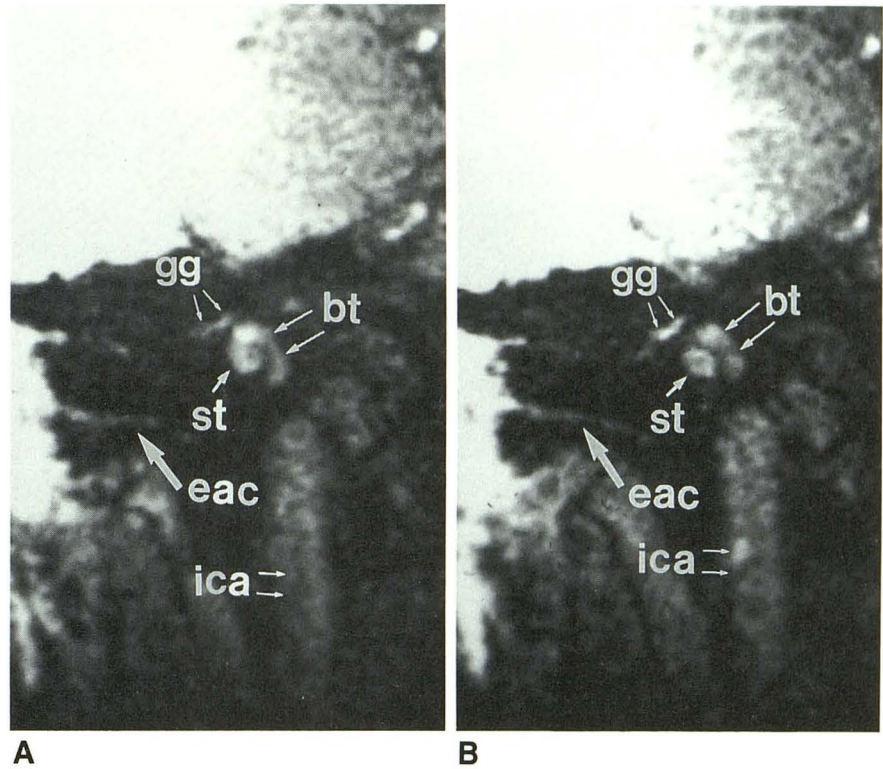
Coronal 3DFT MR images. See key for abbreviations.
